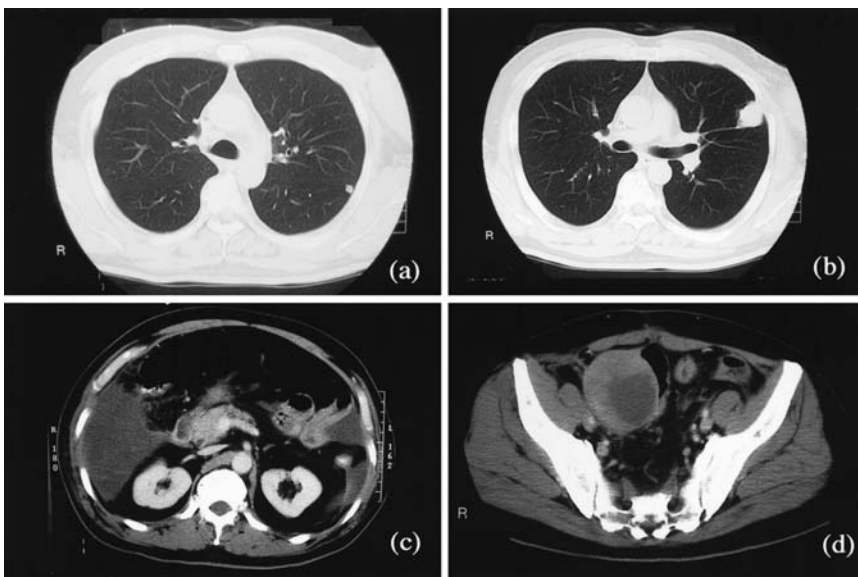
a Computed tomography (CT) scan of the chest revealed a 5-mm nodule extended into S6. b CT scan of the chest shows a 3-cm nodule extended into S3–S4. c CT scans of the abdomen reveal a retroperitoneum mass involving the pancreas head and a large hematoma. d CT scan of the pelvic region shows a large mass extending into the sigmoid colon
